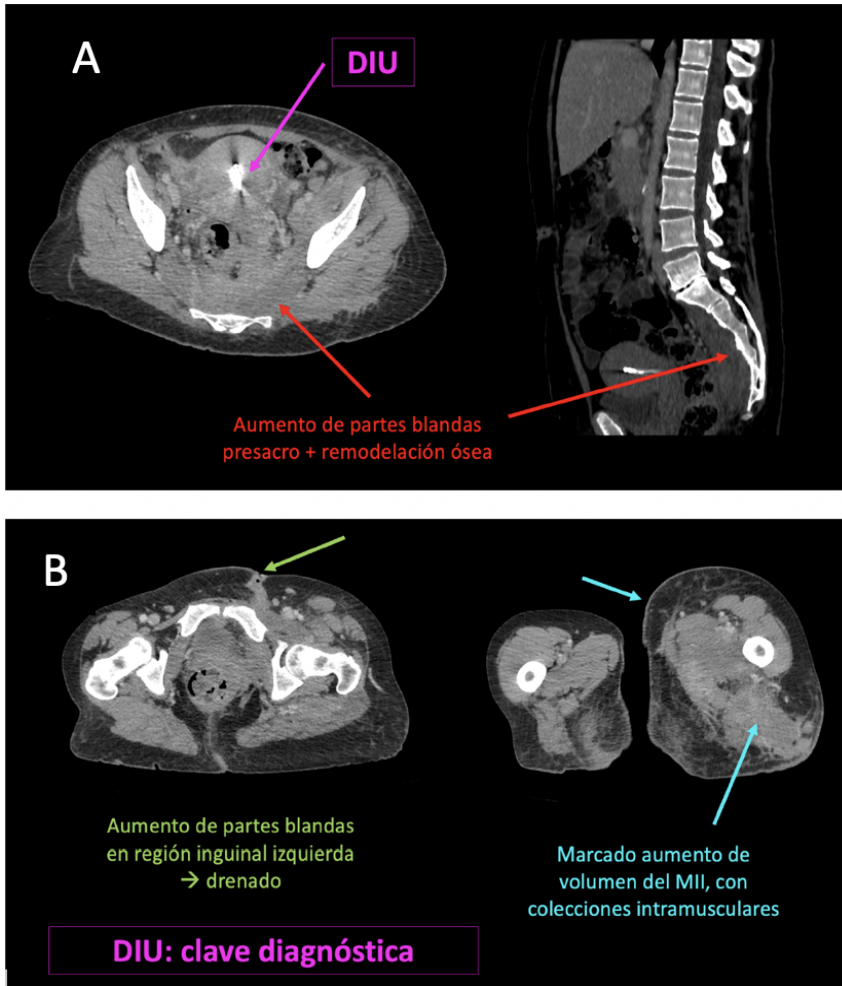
A. Axial computed tomography (CT) scan in the portal phase showing the presence of an intrauterine device (IUD) and demonstrating increased presacral soft tissue, causing visible bone remodeling also observed in sagittal section, indicating a long-standing process. B. Axial CT scans in portal phase at the pelvic and proximal thigh levels revealing increased soft tissue in the left inguinal region, already drained (purulent content), as well as significant enlargement of the left thigh compared to the contralateral side, with multiple poorly defined margin collections within the muscle thickness (suggestive of abscesses).
